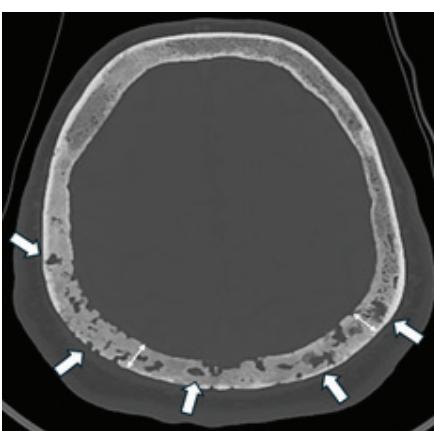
Brain CT, axial slice – bone remodeling in both parietal bones.
